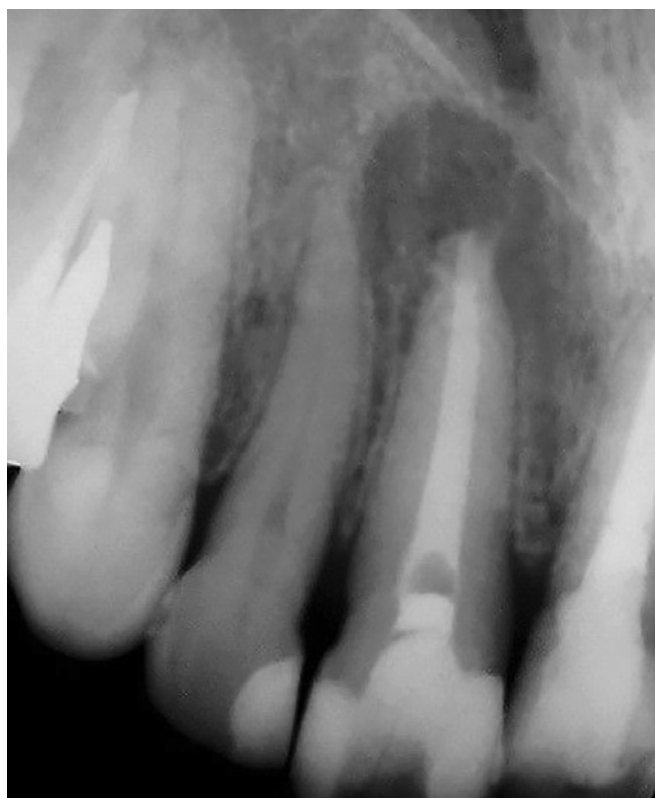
Radiograph shows extruded filling material oozing out of fistula.
